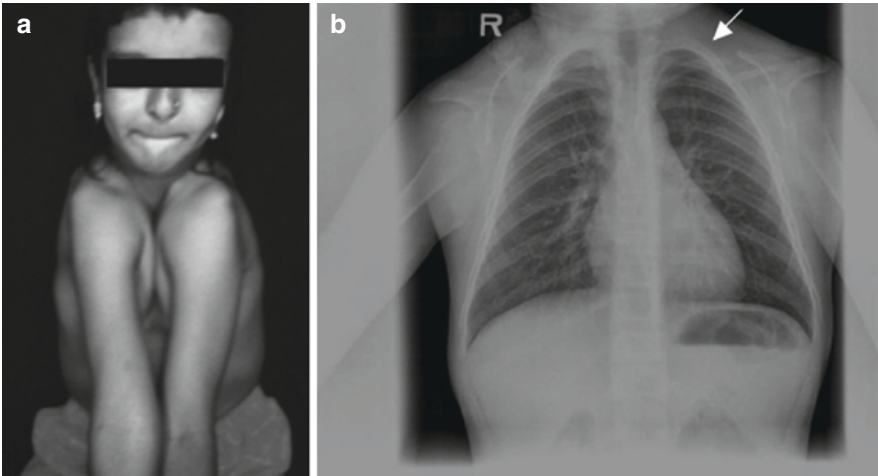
(a) Patient with cleidocranial dysostosis showing the absence of clavicles and curvature of the humeri. (b) Radiograph of the patient in panel A showing hypoplasia of the clavicles (arrow), resulting in downsloping shoulders. (Adapted with permission from Kumar [88]).
